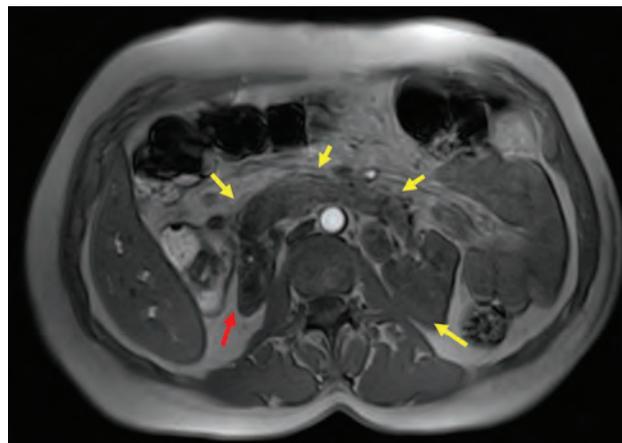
Axial MRI without contrast showing a horseshoe kidney (yellow arrows) with atrophy of the right kidney (red arrow).
